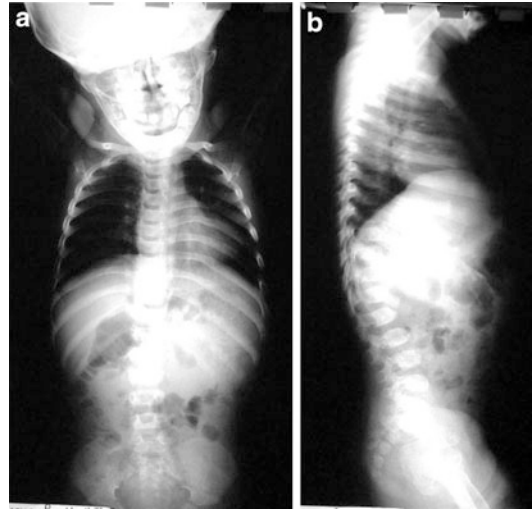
(a, b) Radiographs of the spine (AP and lateral views) show caudal narrowing of lumbar interpedicular distance and the dorsal convexity of the lumbar vertebral bodies
